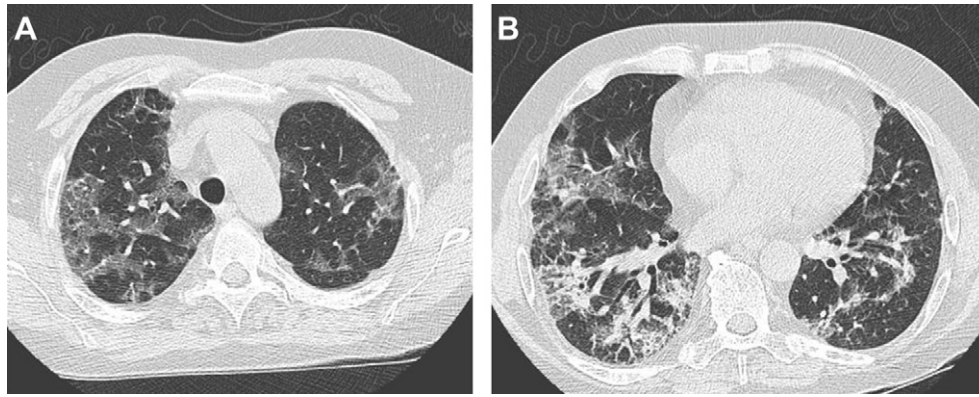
Chest CT-scan showing diffuse bilateral ground glass opacities (A and B) with retraction of both lower lobes suggestive of fibrosis (B).
